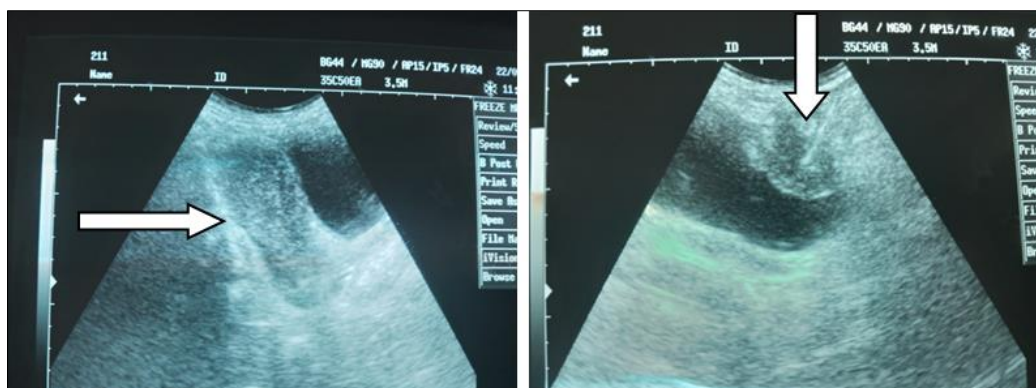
Sonograms of the pelvis showing an empty uterus (horizontal arrow). An IUD demonstrated as a linear echogenic structure within a mass like hypoechoic area in the anterior wall of the urinary bladder (vertical arrow)
